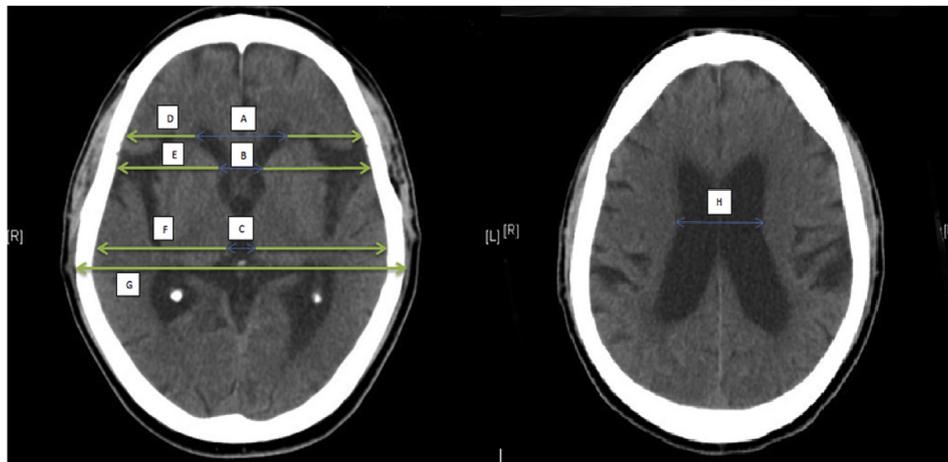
CT indices used in this study. BICAUDATE INDEX = minimum width of lateral ventricles/skull width at the same level = B/E. BIFRONTAL INDEX = maximum width of frontal horns/skull width at the same level = A/D. EVANS INDEX = maximum width of frontal horns/skull width at the level of the third ventricle = A/F. CELLA INDEX = width of the third ventricle/skull width at the same level = C/F. CELDA MEDIA INDEX = maximum width of the skull/width of lateral ventricles = G/H. VENTRICULAR INDEX = minimum width of lateral ventricles/maximum width of frontal horns = B/A.
